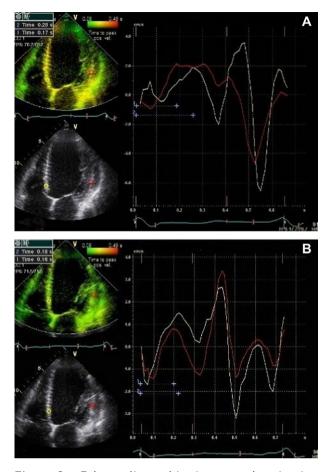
Echocardiographic tissue synchronization imaging (TSI) of LV segments before and after CRT. Before CRT (A) in a patient with LBBB and systolic paradoxical septal motion there was delay in the onset and peak sustained systolic contraction in the septal (red curve) compared with the lateral wall (yellow curve; [delay = 80 ms]). After CRT (B), there was marked improvement in the synchronicity, as reflected by the nearly overlapping of the myocardial velocity curves (delay = 20 ms) and the uniformity of green color in the 2D picture.
